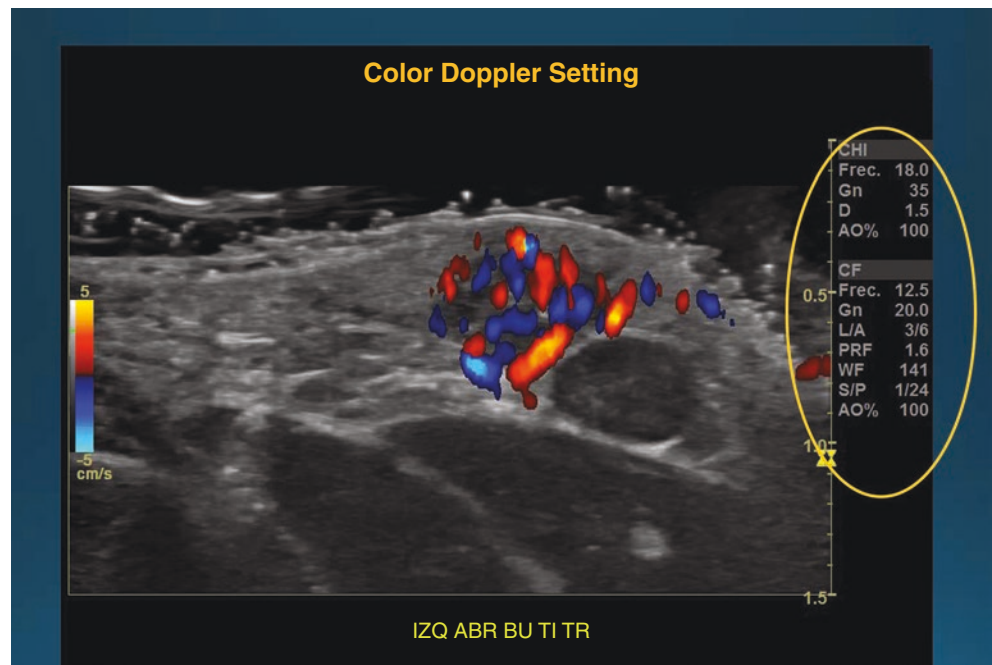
An example of color Doppler setting for dermatologic ultrasound studies.
